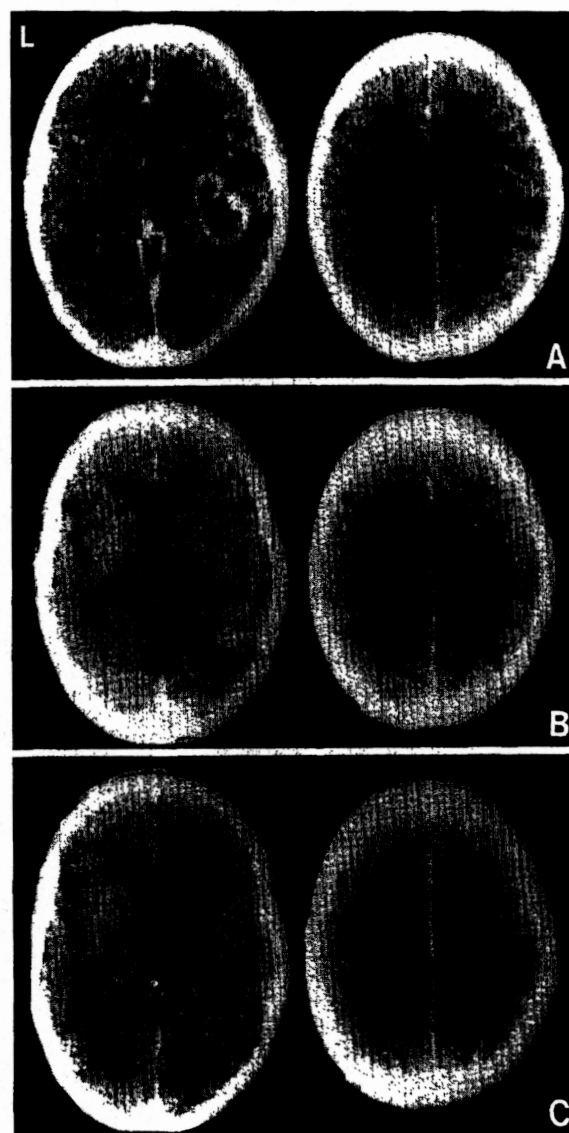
Sequential postcontrast CT scans in Case 2. A: On admission, an enhanced mass in the right temporal lobe and surrounding brain edema are seen. B: Six months after the second operation, the right temporo-occipital region is heterogeneously enhanced without mass effect. A diffuse low-density area in the white matter is also seen. C: Five months later, the enhanced areas are changed.
